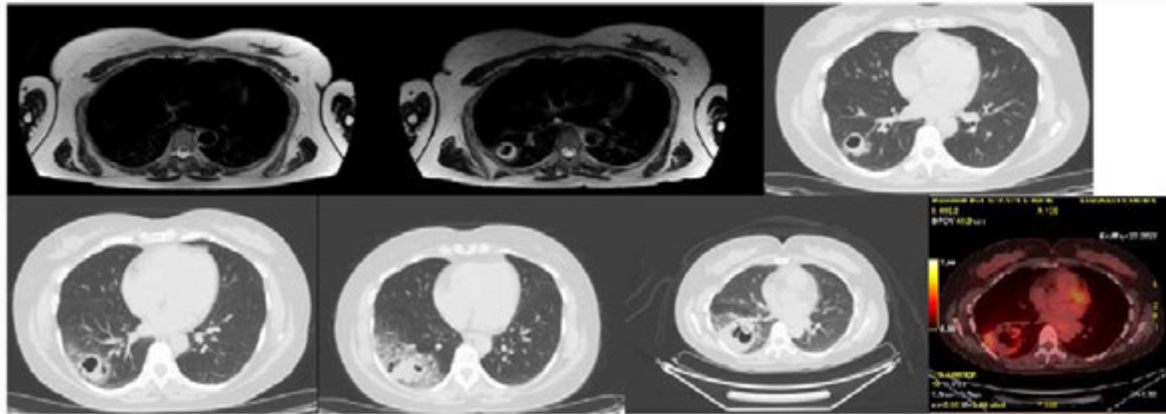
Radiologic evolution of the mass since the first control (2020) to the last (2022). The PET-FDG shows glucidic hypermetabolism.
